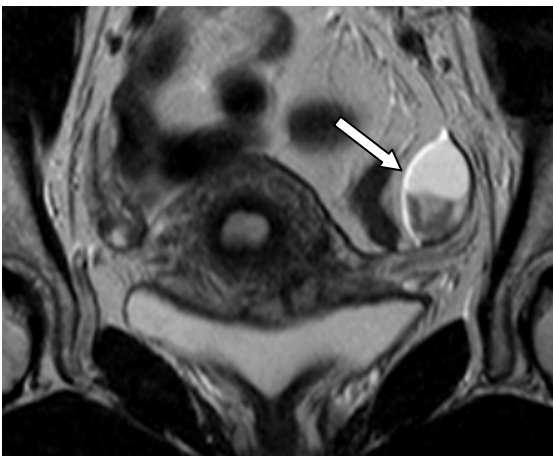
T2-weighted TSE scan in the coronal plane, demonstrating chemical shift artifacts at the surface of the left ovary (containing a high signaling fluid-filled follicle in its cranial half, and a corpus luteum in its caudal half). The arrow indicates the peripheral ovarian rim in the phase-encoding direction, which in this case has turned white.
